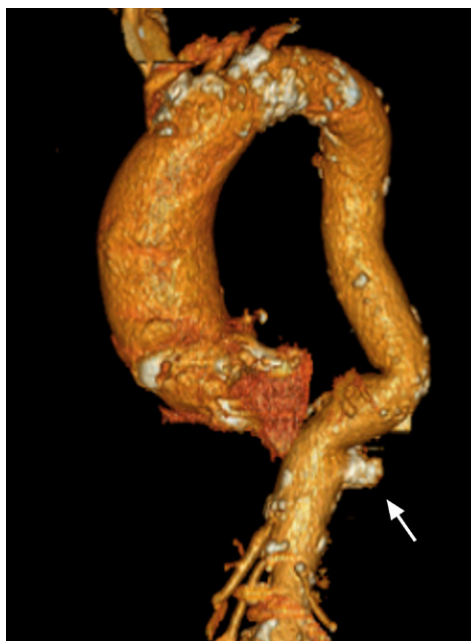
Computed tomogram (3-dimensional reconstruction) of the thoracic aorta shows the dilation of the aortic root and ascending aorta, and the normal size and tortuous course of the descending thoracic aorta. Arrow points to the aortic false aneurysm at the posterior distal thoracic aorta. The reconstruction does not show the obvious site of the aneurysm, probably because of thrombosis.
